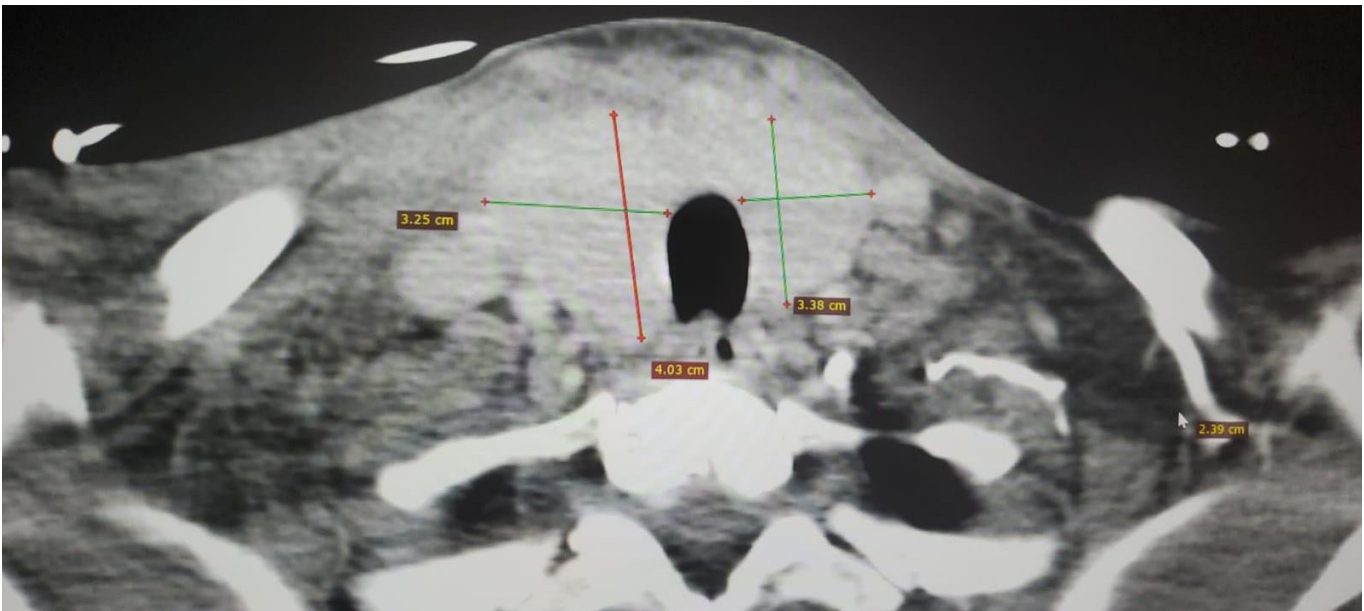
CT scan of Thyroid Goiter
